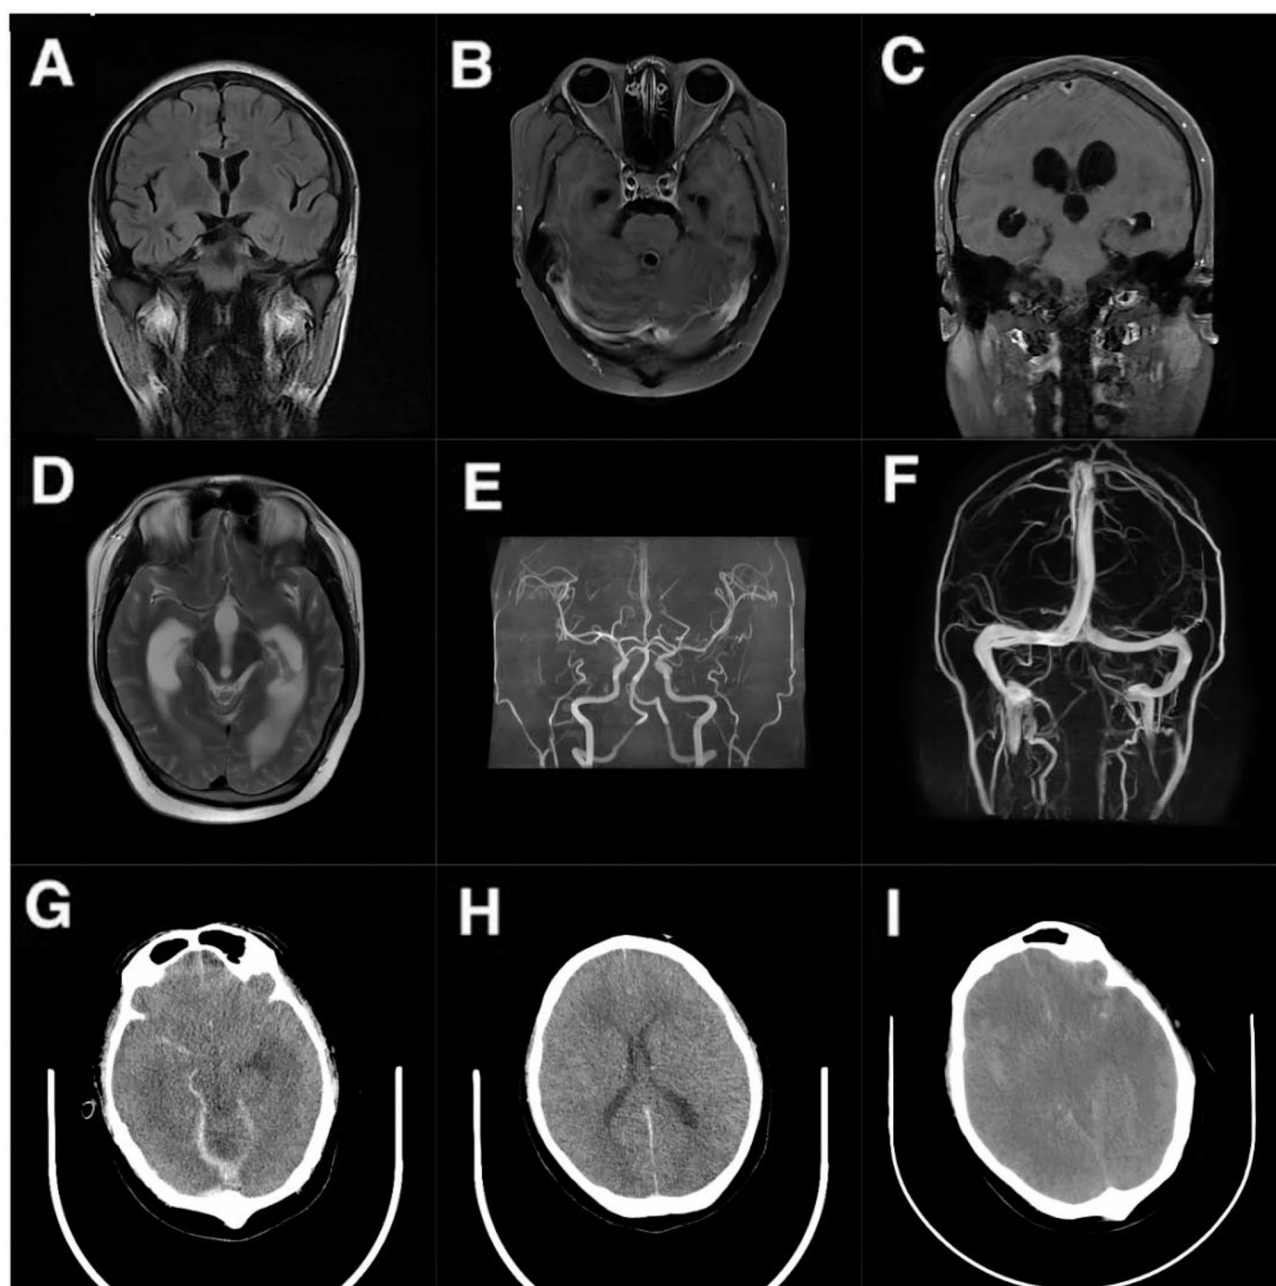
Dynamic changes in imaging results for the patient. (A) Normal brain MRI. (B) Enhanced brain MRI suggests dilatation of the lateral and fourth ventricles, with enhancement seen in the fourth ventricle. (C) Coronal view of brain MRI suggests marked bilateral lateral ventricular dilatation. (D) T2 sequences of brain MRI suggests dilatation of the lateral and tertiary ventricles. (E) Normal brain MRA. (F) Normal brain MRV. (G) Brain CT indicate subarachnoid hemorrhage, compression and swelling. (H) Brain CT suggests swelling with significant compression of the lateral ventricles compared to previous scans. (I) Brain CT showed further progression of subarachnoid hemorrhage and significant brain swelling compared to previous scans
